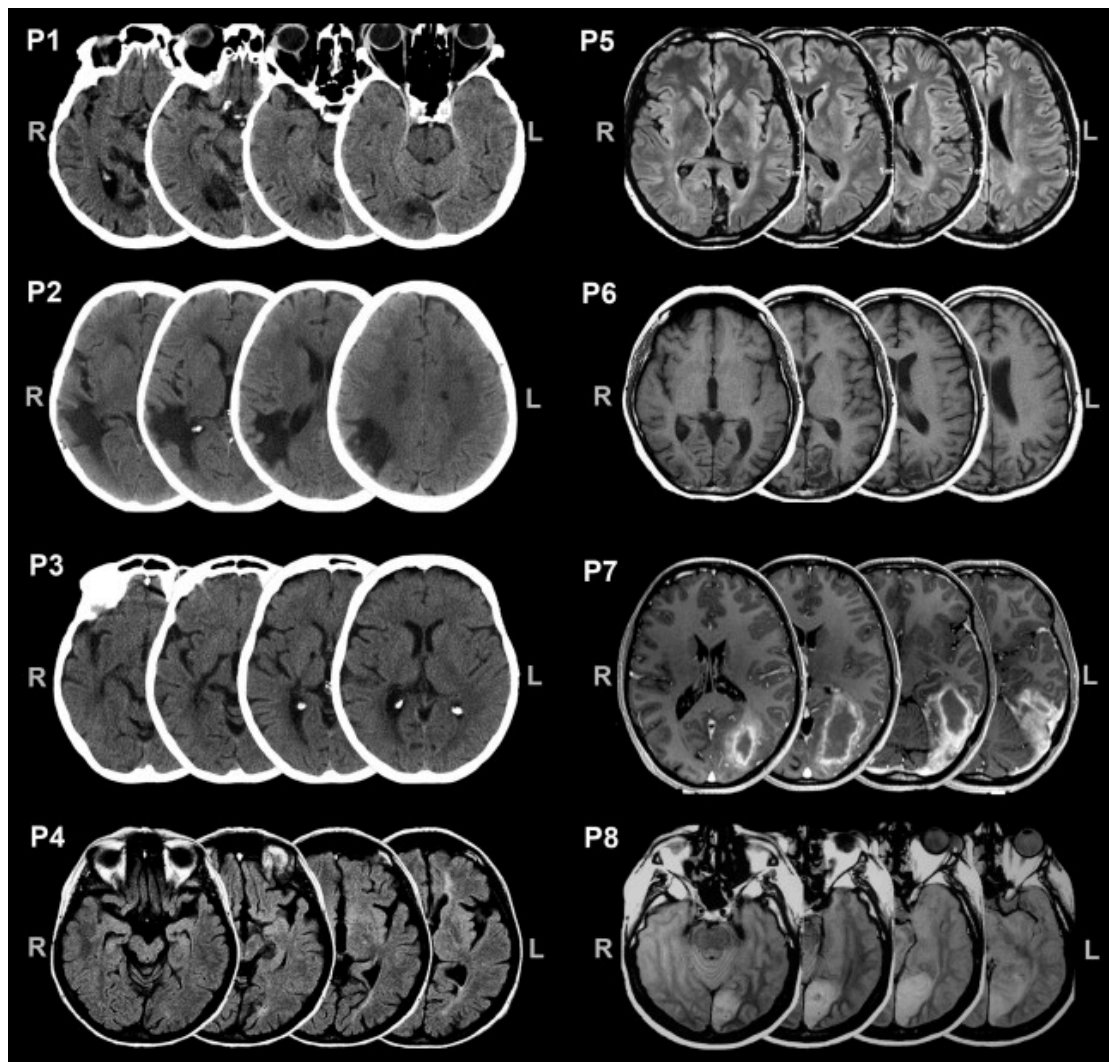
CT or MRI scans of patients in axial views. R = right; L = left.
